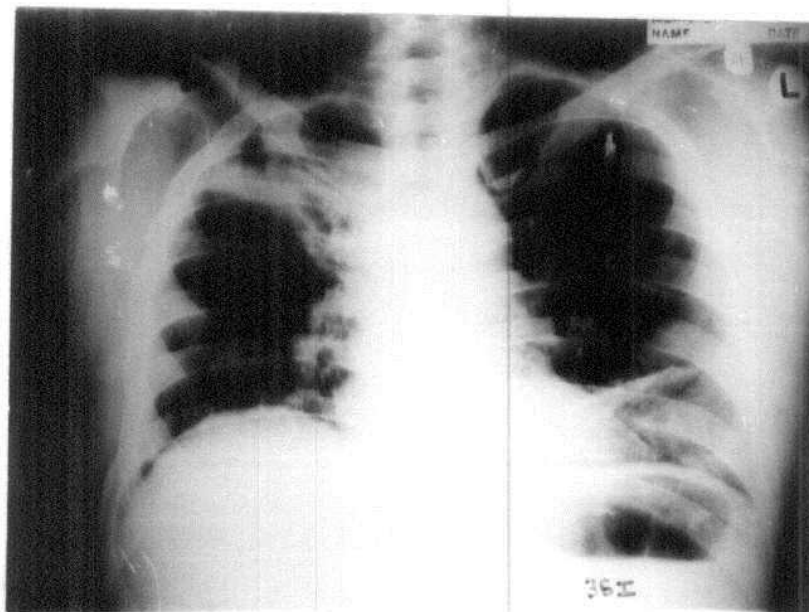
Postoperative chest radiograph for patient No. 36 I (on the 10th. postoperative day) showing partial right upper lobar lung collapse , elevated right coupla of the diaphragm. Left basal linear atelectasis. It was suspected to be left sided pulmonary embolism.
